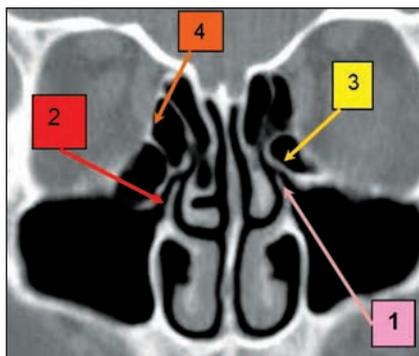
Paranasal sinuses CT scan, bone window, coronal slice: 1. Hyperpneumatization of Haller cell; 2. right uncinatoprocess inserted into the giant ethmoid bulla; 3. left Haller cell; 4. left giant ethmoid bulla
